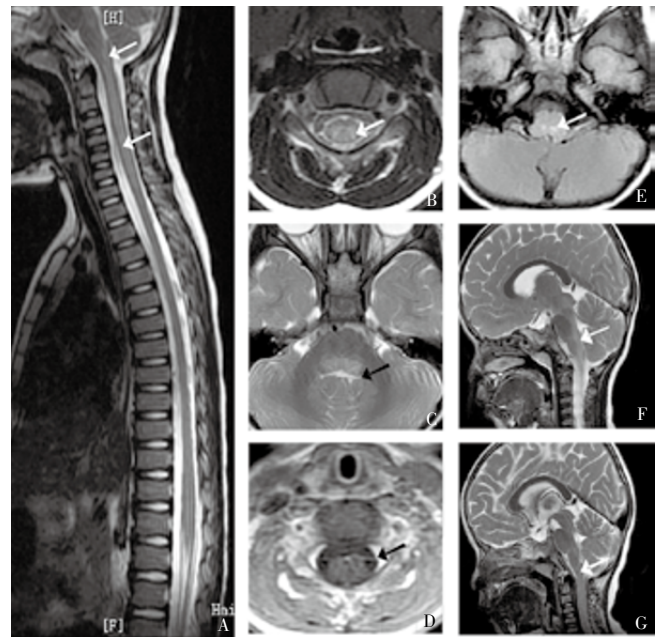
Changes of MRI of case No.2 before and after treatment.
